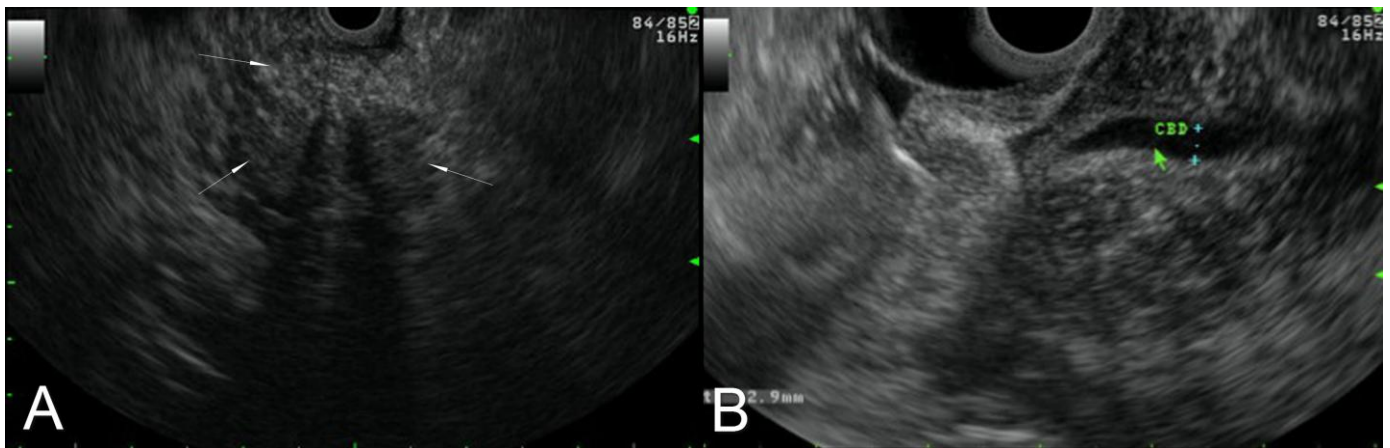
A 27 year-old male with groove pancreatitis. Endoscopic ultrasound demonstrates a heterogeneous and predominantly hypoechoic mass (arrows, a) with scattered calcifications and poorly defined margins located between the pancreatic head and the duodenum (a, b), mild dilatation of the common bile duct is appreciated with long and smooth tapering in the distal third (b). (Transducer frequency - 7.5 MHz).
